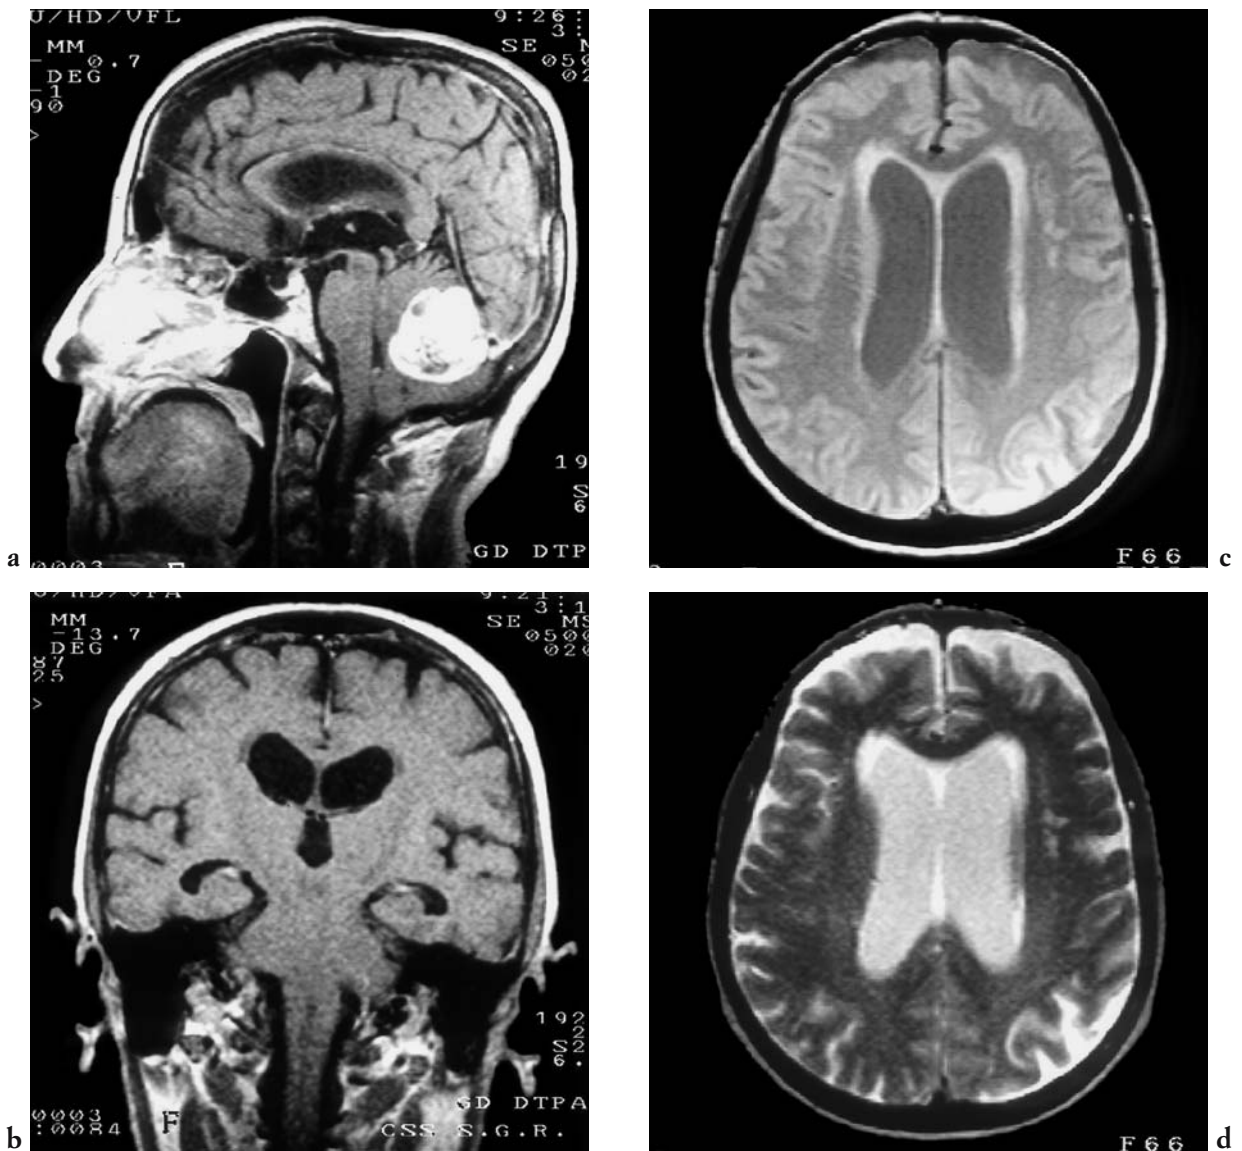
Neoplasm of the cerebellar vermis with obstructive hydrocephalus. The MRI examination shows a contrast enhancing mass (a) likely originating within the cerebellar vermis that compresses the 4th ventricle and has resulted in obstructive hydrocephalus (b). The T2-weighted images reveal transependymal extravasation of CSF into the periventricular white matter (c, d).
